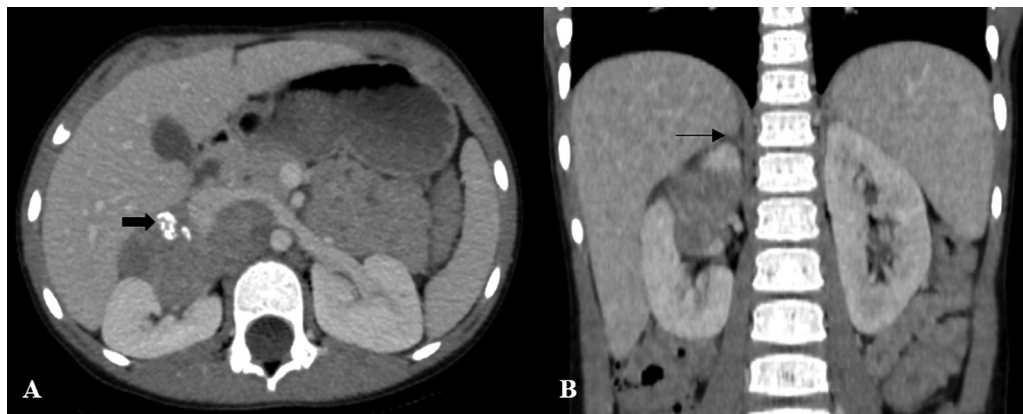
(A,B) Axial and coronal contrast-enhanced computed tomography (CT) of the abdomen in a 4-year-old girl shows an ill-defined heterogeneously enhancing soft-tissue mass with internal foci of coarse calcifications (arrow in A) centered in the right anterior pararenal space of the retroperitoneum displacing the inferior vena cava (IVC), left renal vein, and pancreas anteriorly. No foci of fat attenuation are noted. No spinal canal extension was noted. The right adrenal gland is normal (thin line arrow in B). It was a proven case of extra-adrenal neuroblastoma.
